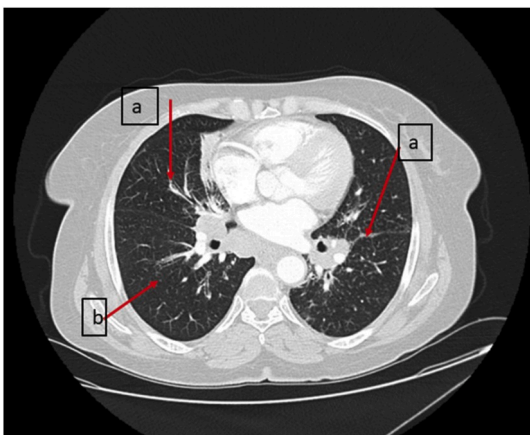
Thoracic CT scan (parenchymal window): proximal peribronchovascular thickening associated to peribronchovascular, centrilobular and perilobular nodules (arrows).
